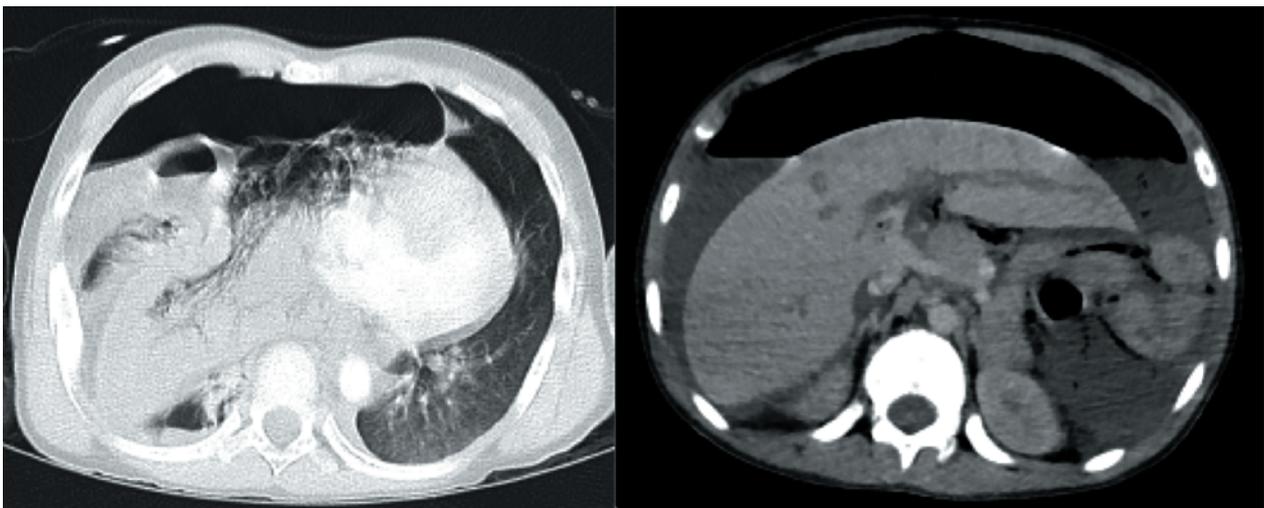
Thoracoabdominal CT-scan at 8 years of age.
